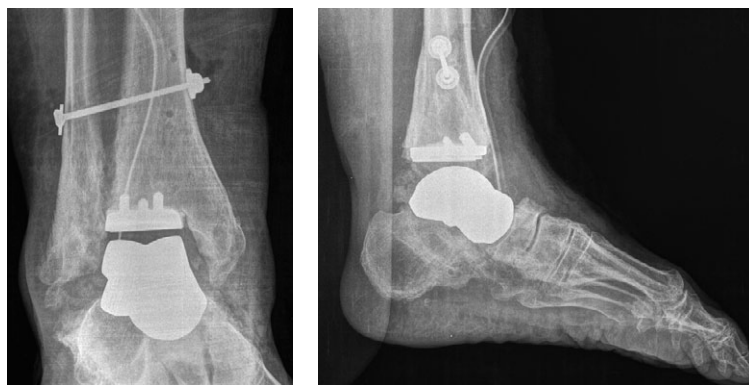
Intraoperative X-rays of the ankle joint in the AP and lateral planes: the presence of a talus implant, a tibial component of the ankle joint endoprosthesis, syndesmotomic screw is visualized; restoration of the ankle joint and foot contours
